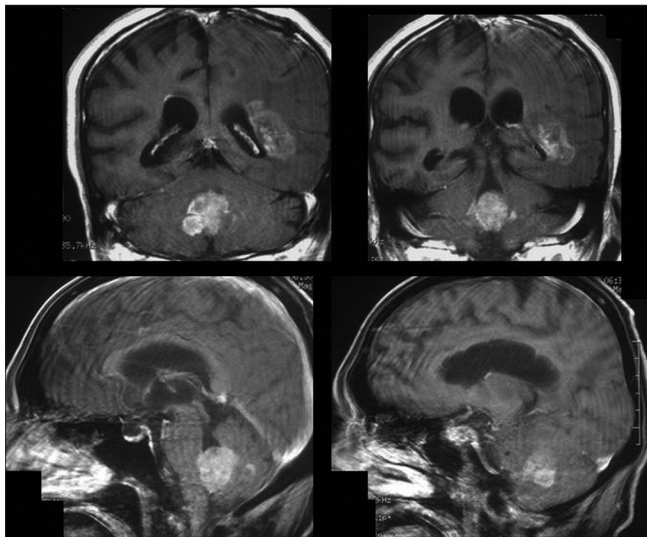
MRI performed about 1 year after initial hospitalization. Cerebellar tumor was observed and enlarged with hydrocephalus. It was not detected in the initial MRI at the first hospitalization
